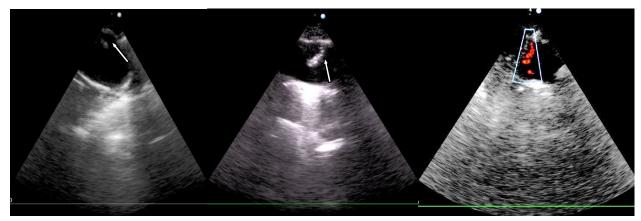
Echocardiography showing small false lumen
